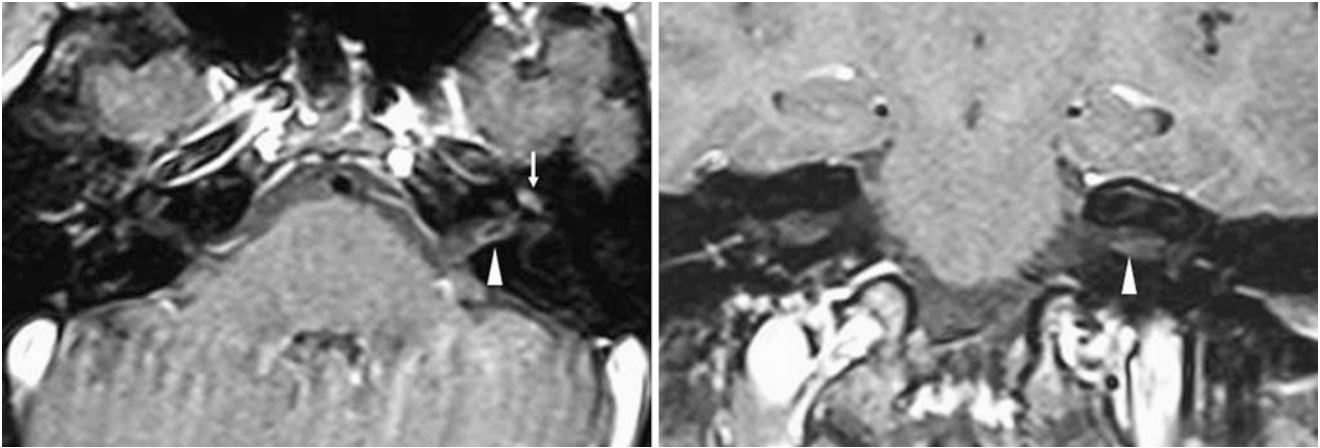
A 50-year-old patient with a history of dizziness and giddiness underwent an IAC protocol MRI at 1.5 T. Postcontrast FS SET1WI in the axial (*left*) plane depicts normal mild, wispy perineural enhancement surrounding the intracanalicular portion of the left CN7 (*arrows*).
